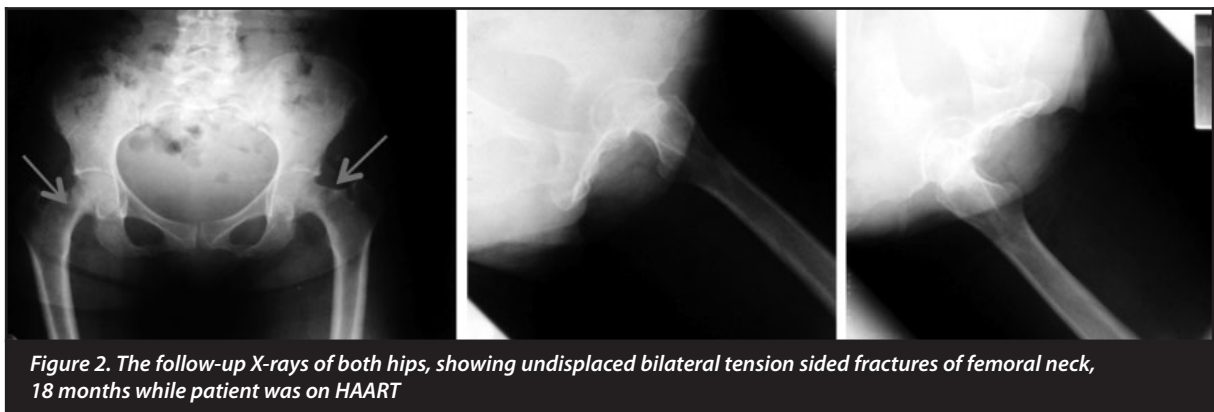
The follow-up X-rays of both hips, showing undisplaced bilateral tension sided fractures of femoral neck, 18 months while patient was on HAART
